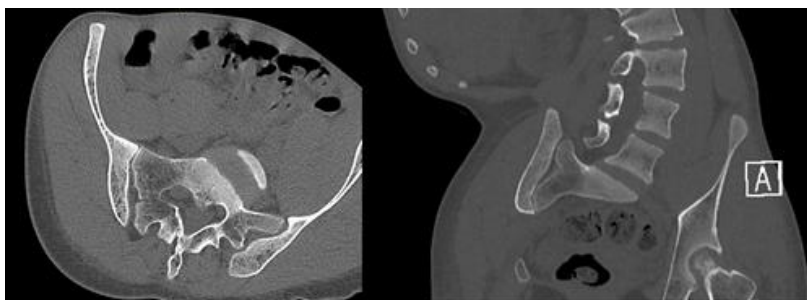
Computed tomography (CT) images show the rotation of sacrum and pelvis obliquity (PO).
